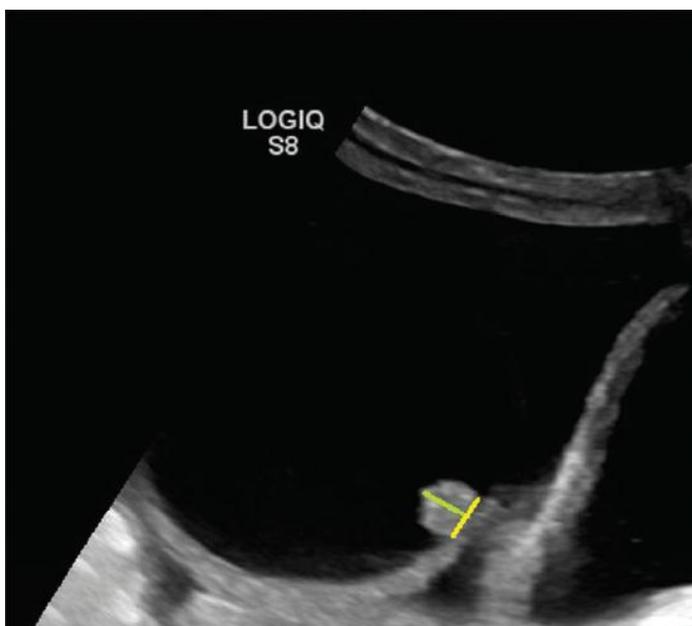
Different adnexal lesions with varying colour score patterns on ultrasound (USG) images: A colour score of one, a colour score of two, a colour score of three, and a colour score of four
